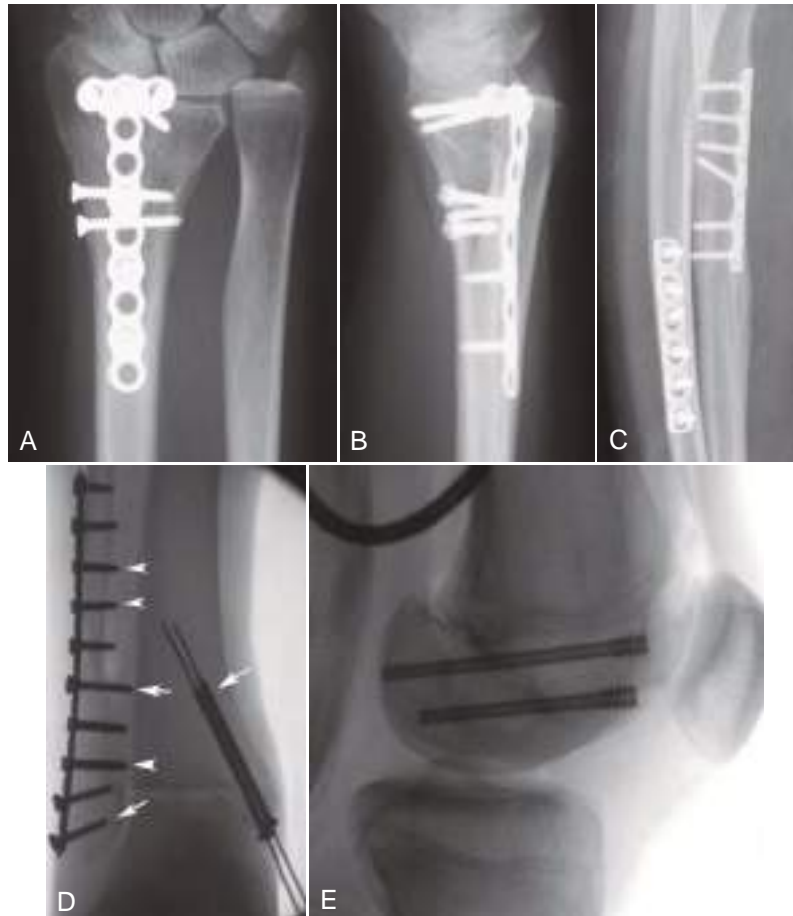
Internal fixation with plates and screws. AP (A) and lateral (B) radiographs show dorsal T-plate fixation of distal radius fracture. Also note the two lateromedial transverse screws. (C) Forearm fractures in adult bones fixed with cortical compression plates. The slots for the screw heads are designed to force the fragments toward the center of the plate. Such compression increases apposition of bone fragments and thus speeds healing. (D) Screw types. Screws designed to gain purchase in cortex have fine threads (*arrowheads*). Screws designed to gain purchase in softer trabecular bone have wider threads (*arrows*). The medial malleolus screws are lag screws. The gap (lag) between the threads and the head allows compression as the screw is tightened. (E) Differential thread screws. This child had a coronal plane fracture across the femoral condyles. The screws were placed from an anterior approach. Note the difference in the threads: the leading edge (more posterior) threads have higher pitch (i.e., are spaced farther apart). As both threads bite, the anterior and posterior bone fragments are compressed together. A similar but smaller screw called a Herbert screw is frequently used to fix scaphoid waist fractures.
